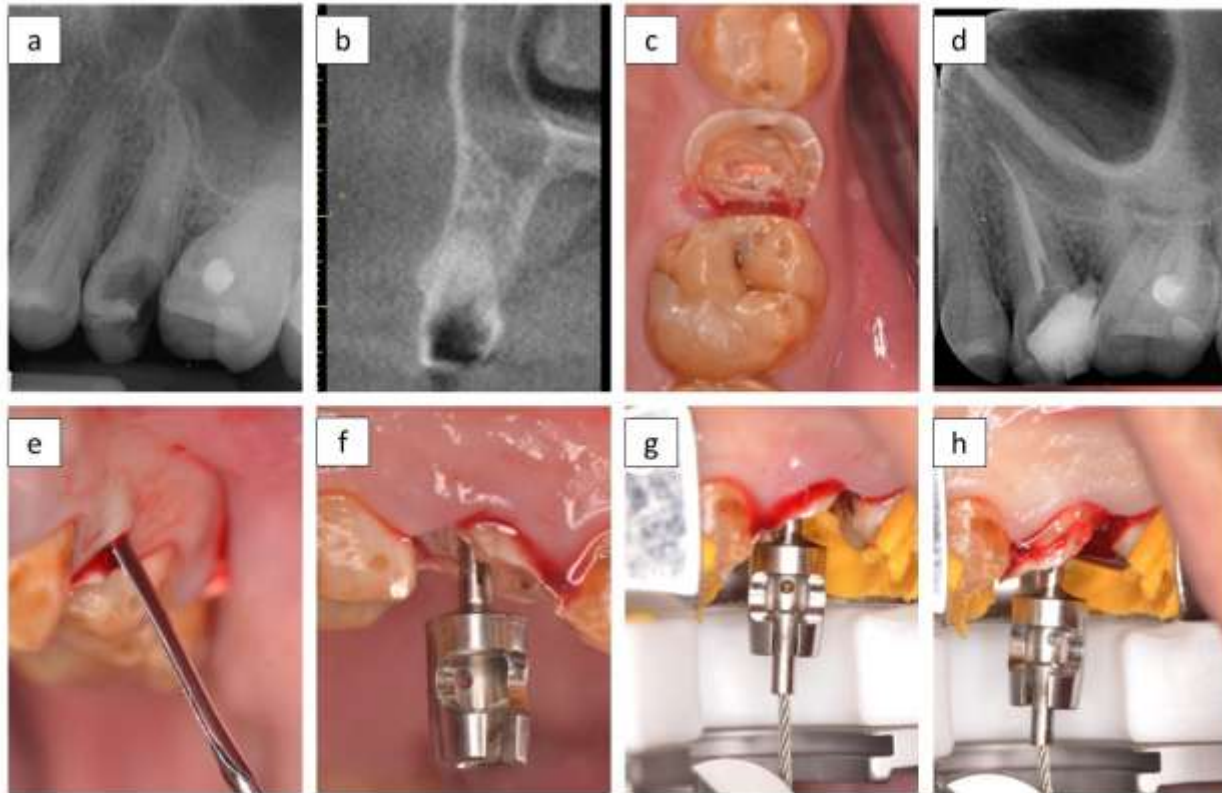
a: preoperative periapical x-ray for tooth #25 showing the deep distal caries, b: cross-sectional view showing intact buccal bone around tooth, c: completing root canals obturation, d: periapical x-ray following endodontic treatment, e: gingival detachment with periotome #1, f: extraction screw inserted into palatal canal, g: the benex extraction system, h: Surgical extrusion of tooth #25.
